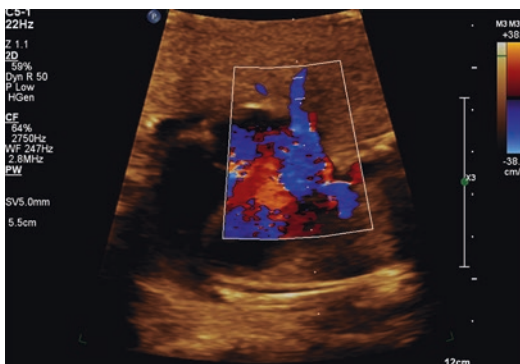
Proper placement of the PW Doppler sample volume in the pulmonary vein just before the entrance into the left atrium at an angle of insonation that is parallel to the pulmonary vein. Using a Philips Epiq machine with a C5–1 MHz curvilinear probe
